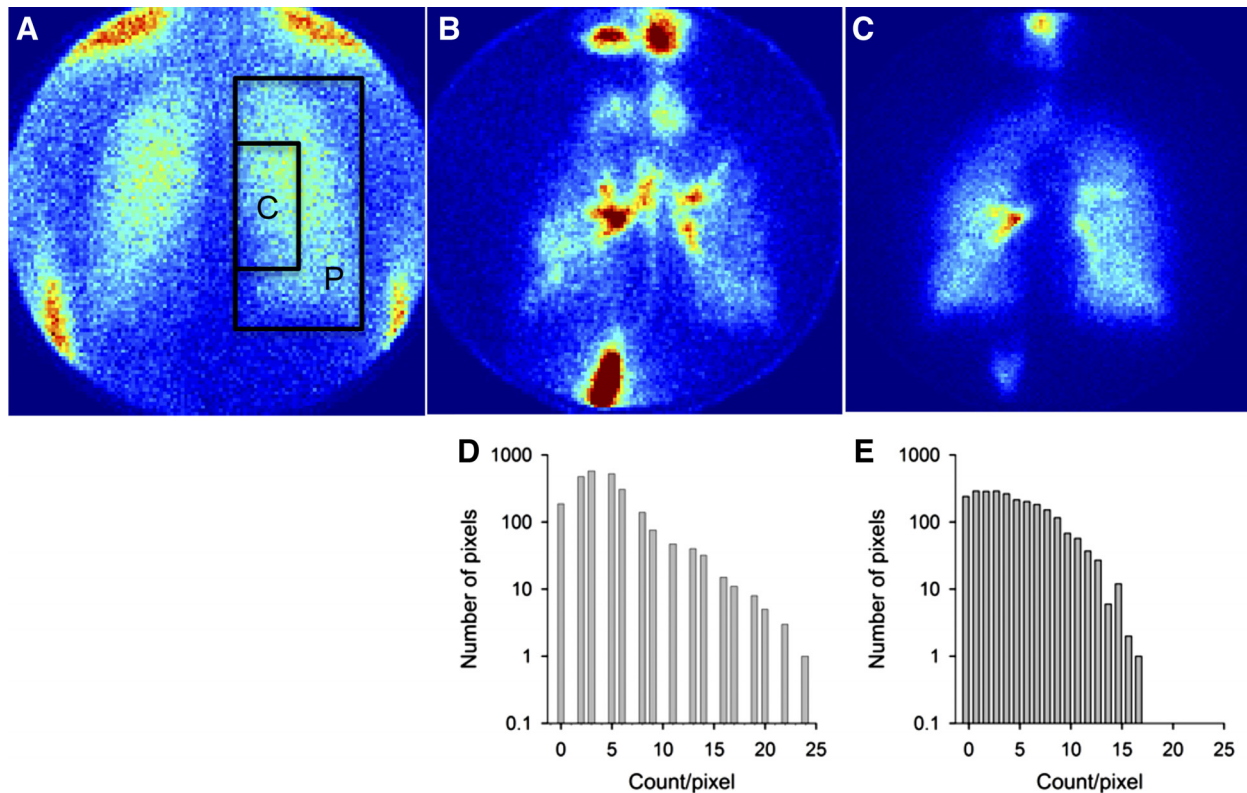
Gamma scintigraphy images obtained in one subject. A: central (C) and peripheral (P) regions of interest were defined based on the transmission scan. Deposition images along with histograms of activity counts from aerosols inhaled in microgravity ( $\mu\text{G}$ ; B and D) and on the ground (1G; C and E) are also shown. Images in B and C were normalized by the total count in the right lung. The amount of deposition increases from blue to red. Note that, in  $\mu\text{G}$ , because of the absence of gravitational sedimentation, fewer particles deposited in the P region than in 1G, leading to significant differences in the histogram distributions.
